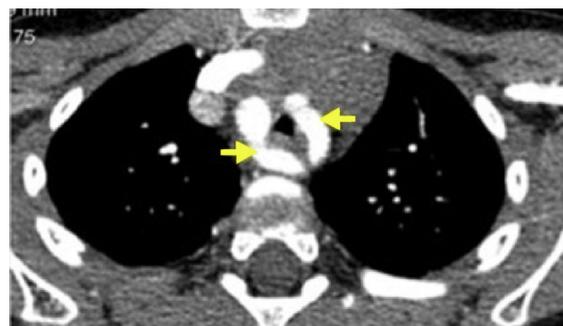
Thoracic computed tomography (angio-CT) angiography, axial view, showing two aortic arches (arrows) forming a double aortic arch, which surround the airway and reduce tracheal caliber. The right aortic arch is dominant.
